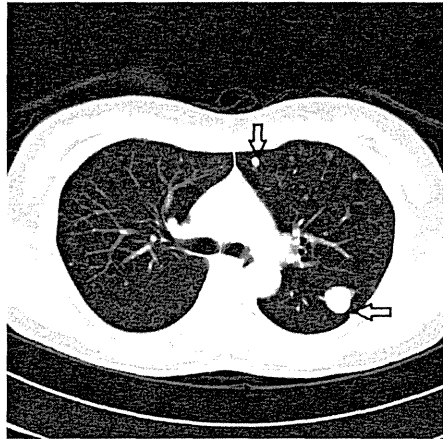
Computed tomography of the chest showing multiple lung lesions. Several nodules are visible in both lungs.
